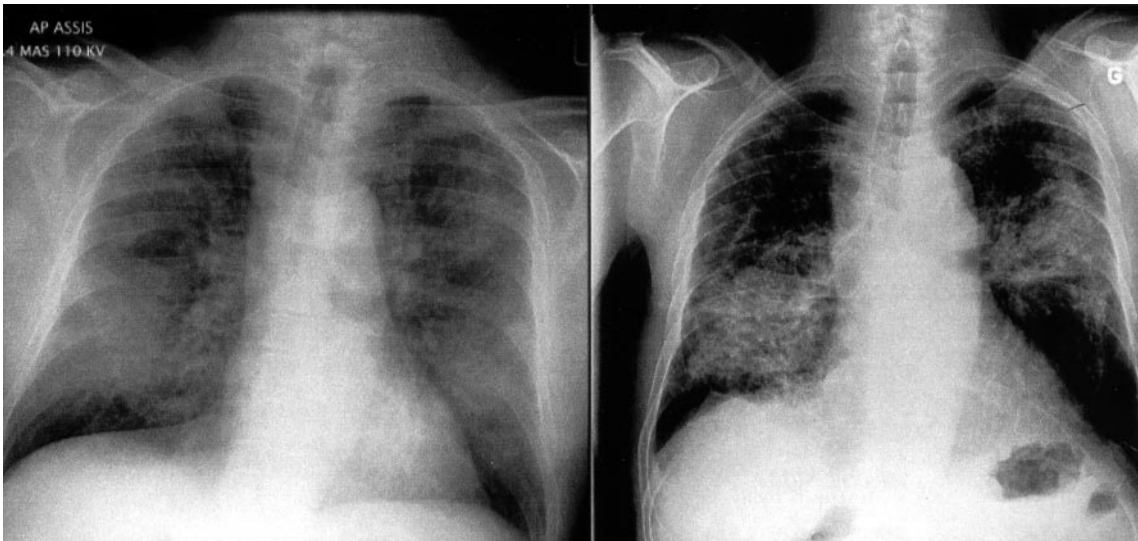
Chest radiograph on admission (left) and 1 month later (right).
